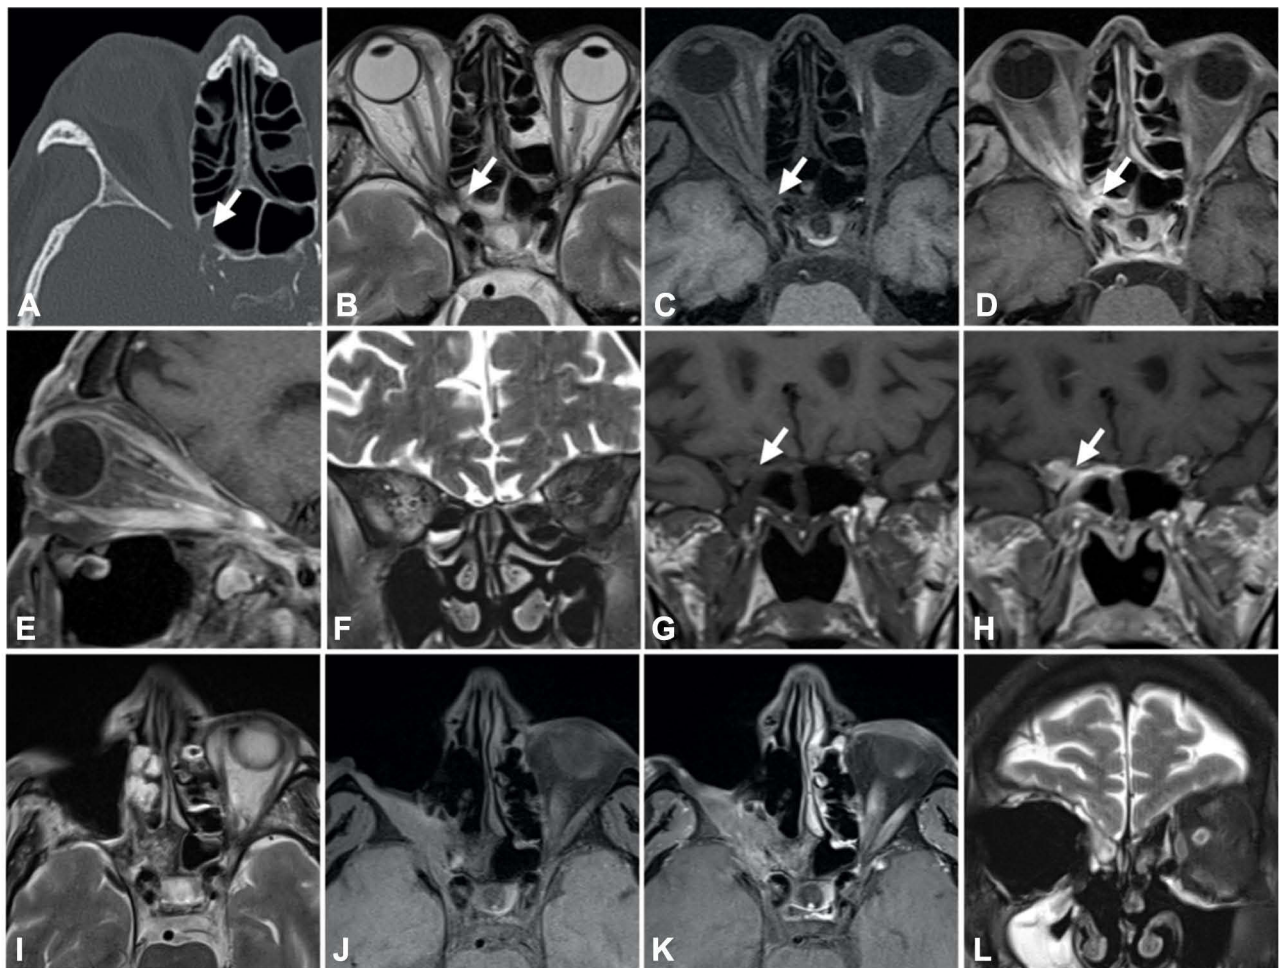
Orbit Computed Tomography (A) and Magnetic Resonance Imaging (B–H) at presentation depicted a defect on the lateral wall of the right sphenoid sinus (arrows in (A–D) and in (G) and (H)), that was partially opacified by hyperintense content on T2 weighted-images (B). It was observed an enlargement of the right orbital fissure and optic canal, with abnormal contrast enhancement that extended to the ipsilateral cavernous sinus, orbital apex and orbital fat, accompanied by right inferior rectus muscle enlargement and enhancement. Thickening of the right optic nerve and nerve sheath enhancement were also present. Post-operative Orbit Magnetic Resonance Imaging (I–L) showed right orbit exenteration, without abnormal enhancement in the orbital compartment and remaining focal enhancement of tissues around the anterior clinoid process and adjacent to the defect on the lateral wall of the right sphenoid sinus.
